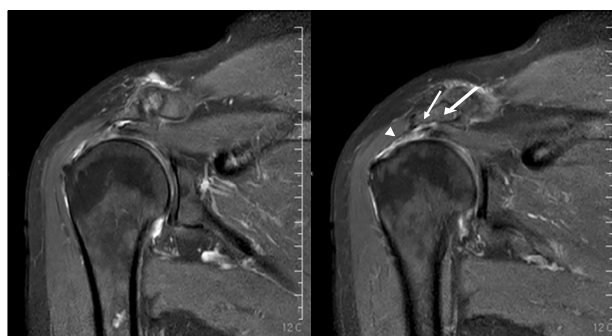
Initial T2-weighted coronal magnetic resonance imaging showing irregular subacromial bone erosion (arrows) and rotator cuff retear (arrowhead).
